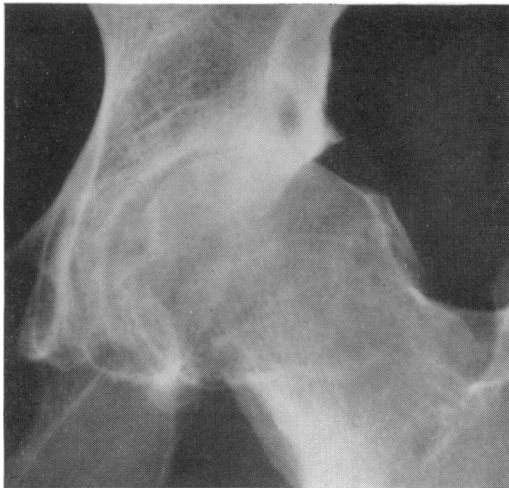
A radiograph of the hip of a patient complaining of moderate pain for eighteen months. The cystic lesion in the roof of the acetabulum is surrounded by dense bone and the superior joint space is almost absent. The range of flexion under anaesthesia was almost full*
